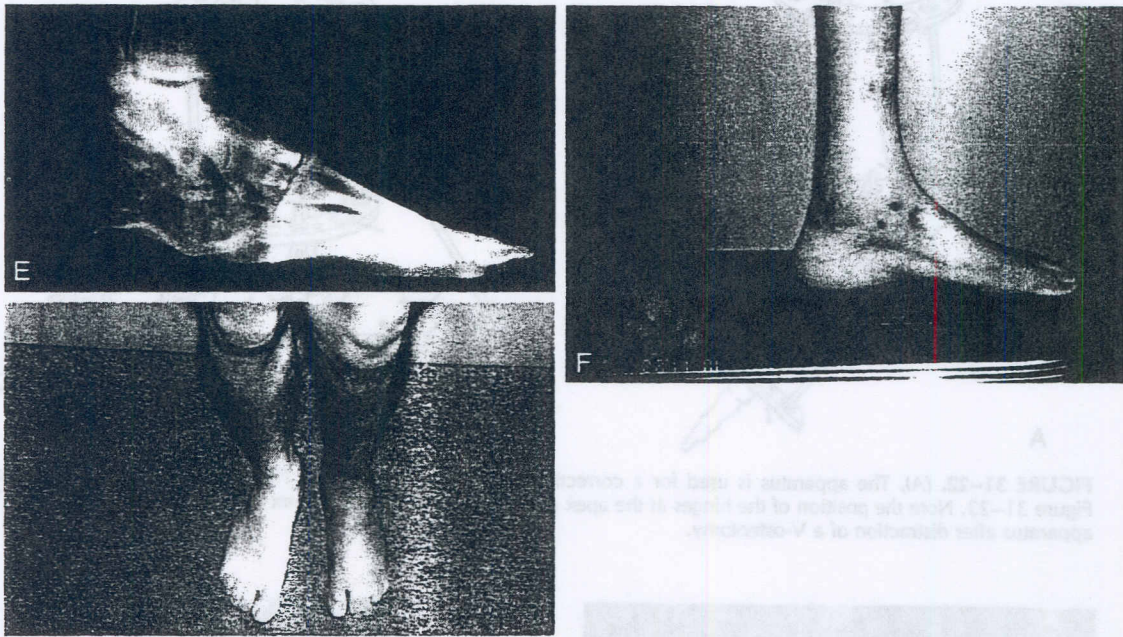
Continued* (E), The lateral standing radiograph after distraction demonstrates that the foot is plantigrade. Opening wedges of new bone were generated anteriorly and posteriorly in the talus and calcaneus. (F), The foot is plantigrade postoperatively. The normal longitudinal arch is restored, and the equinus deformities of both the hindfoot and forefoot are eliminated. (G), The adductus deformity has also been corrected through the talocalcaneal neck portion of the V-osteotomy. (Courtesy of Dror Paley, M.D.)
